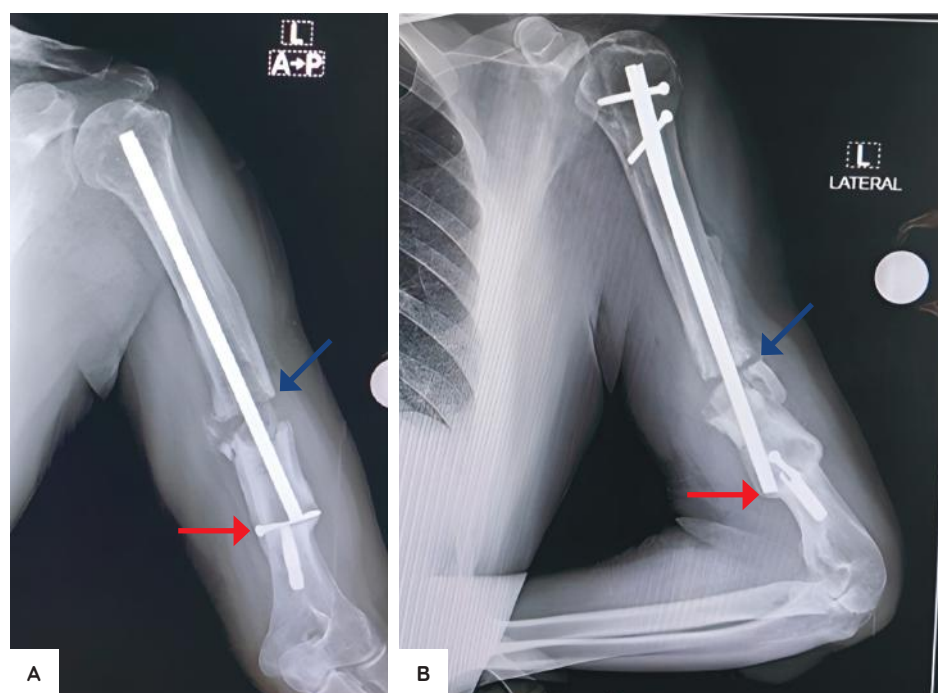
Anteroposterior (A) and lateral (B) radiographs of the left humerus demonstrating implant failure, with breakage of the intramedullary nail at the distal locking screw hole (red arrow), persistent fracture gap at the midshaft nonunion site (blue arrow), and a healed distal fracture segment.
